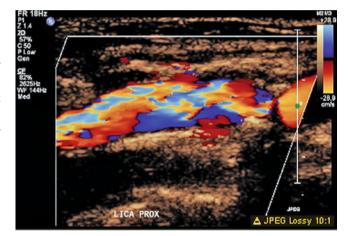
Color duplex ultrasound of the internal carotid artery: color bruit
